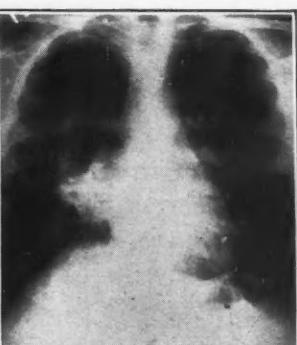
Routine x-ray in a known diabetic of four years duration; no symptoms or signs. Two years later active bilateral pulmonary tuberculosis developed.
